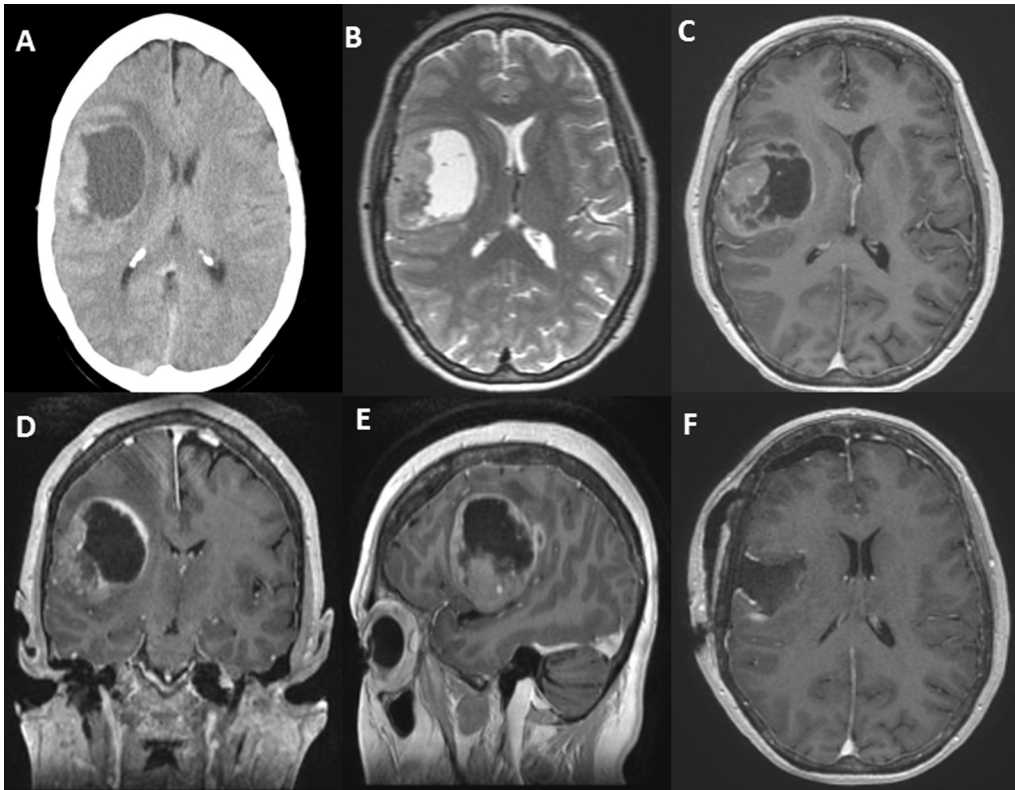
(A) Head CT showed right side posterior frontal mass with solid and cystic component, (B) MRI (T2W) showed right posterior frontal heterogeneous mass with solid part at periphery, (C) MRI Contrast (Axial) showed enhancement of solid part, (D) MRI Contrast (Coronal) showed tumor involving the inferior frontal gyrus, (E) MRI (Sagittal) showed solitary lesion, (F) MRI Post-op (axial) gross total resection of tumor.
